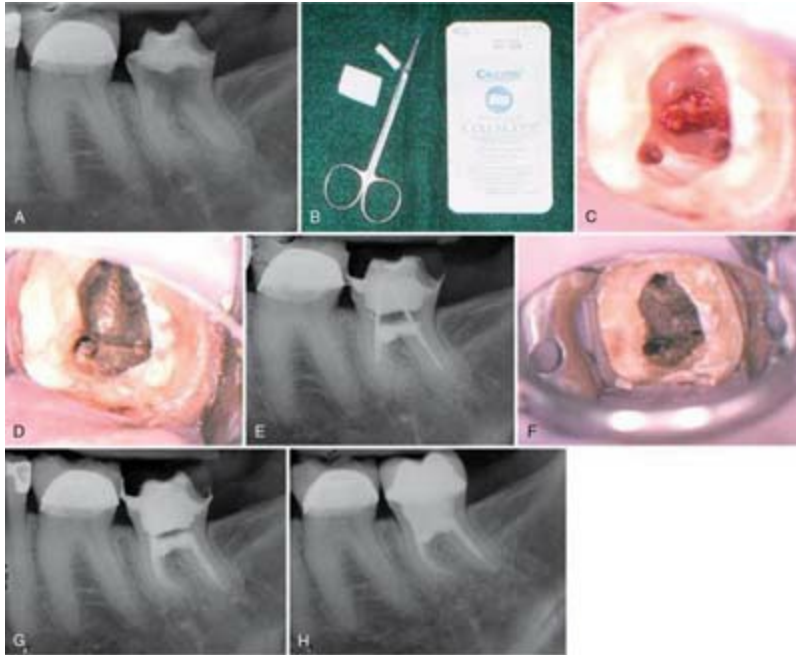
A, Large furcal perforation created during an attempt at endodontic access. B, Colla-Cote (Integra Life Sciences, Plainsboro, NJ) to be used as an external matrix material to recreate the external root contour. C, Canals have been found, preliminarily instrumented, and the external matrix has been placed. D, Canals are protected from being blocked using large endodontic files cut off above the orifice. MTA has been placed into the defect. E, Radiograph showing the initial repair with MTA recreating the vault of the furcation. F, On the second appointment, the blocking files are removed with difficulty since the MTA has flowed into the flutes and set. At this time, endodontic therapy is completed as normal. G, Postobturation radiograph. Note the radiolucency in the furcal vault, which represents the Colla-Cote external matrix material. H, Nineteen-month reevaluation. The patient is asymptomatic and there is evidence of healing in the furcal vault area.
